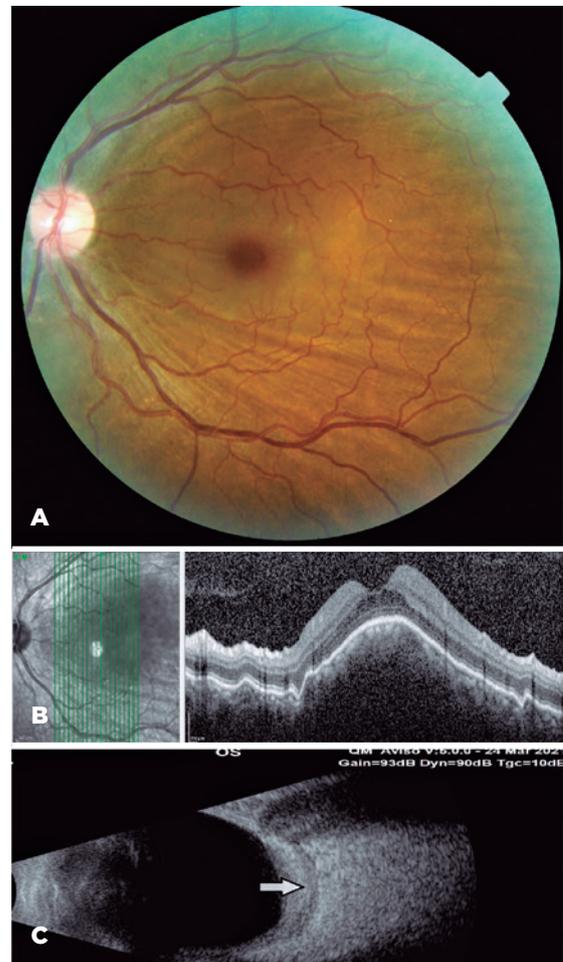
Preoperative findings. (A) Choroidal folds on the fundus. (B) Optical coherence tomography shows macular elevation and choroidal folds. (C) Orbital ultrasonography image of the T-sign (indicated by arrow).
